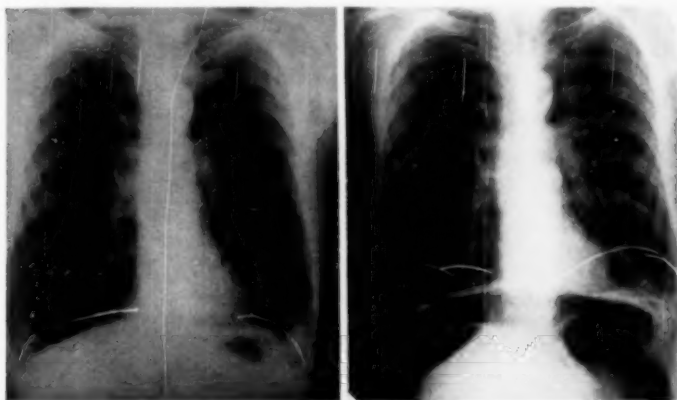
Case 4: From x-ray films showing limits of maximal diaphragm excursion before and after pneumoperitoneum treatment. For a description of technique, see legend, figure 2.
